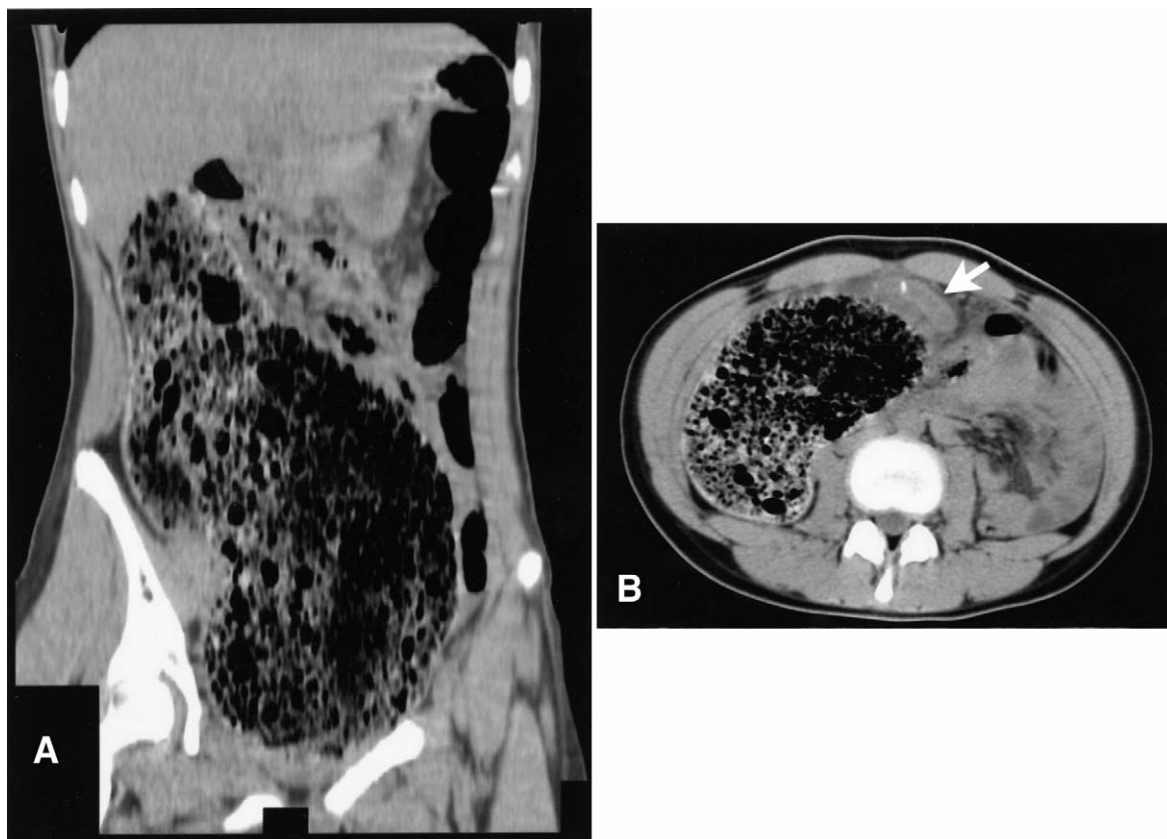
Preoperative CT findings. A, A massive amount of feces was present in the severely distended duplicated right colon. B, The appendix was shifted to the midline of the abdomen and contained calcified fecaliths.
